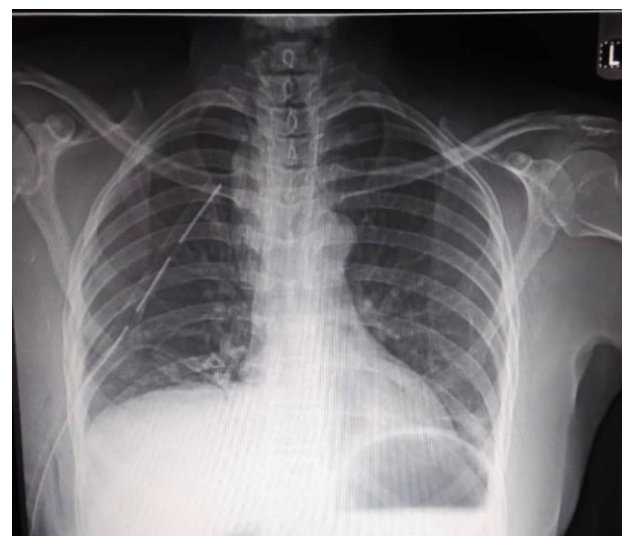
Chest X-ray taken on Post-operative Day-1
